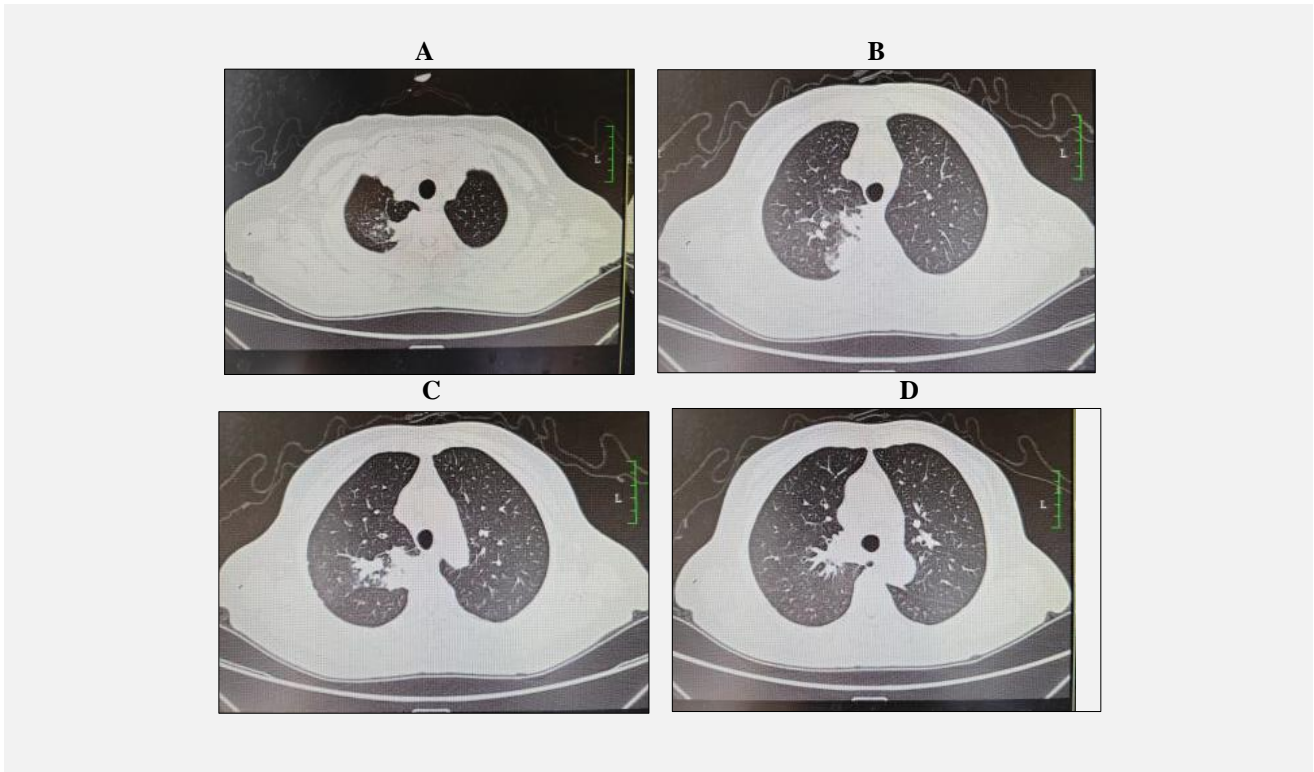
Repeat chest CT after initial treatment suggested an increase in the number of upper lobe-like hyperdense shadows in the right lung compared with that on admission, with well-defined borders, which was considered to be an inflammatory lesion.
